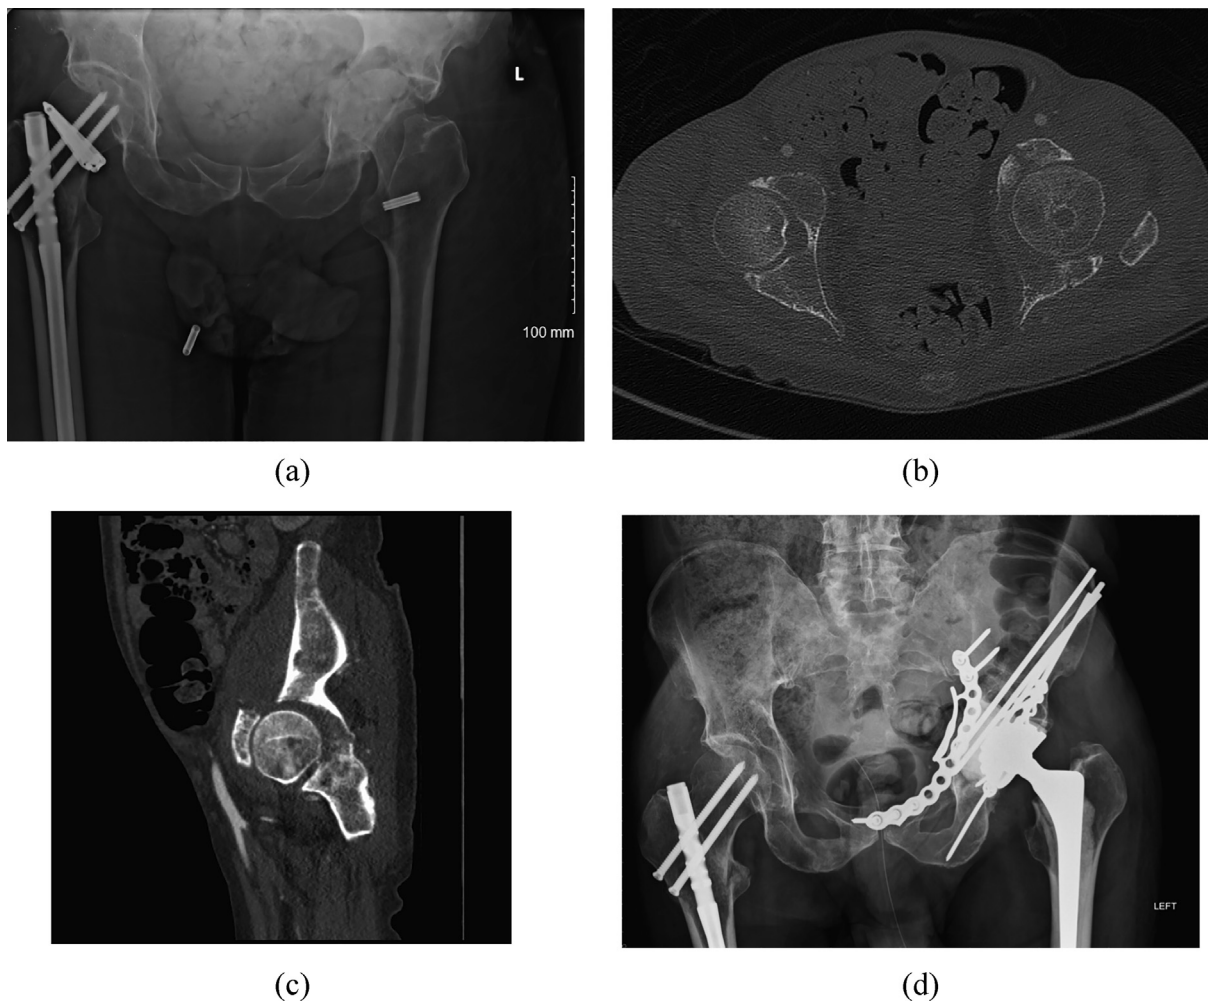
(a to c) Preoperative radiographs and CT scan images of a 58 year old with prostate cancer and a pathological acetabular fracture (d) Postoperative radiographs following Harrington Plus Reconstruction.
